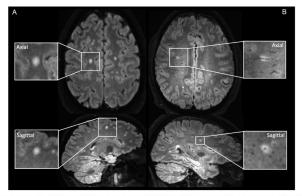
(Larger view file uploaded separately): Axial and sagittal views of 3T FLAIR⁴ brain MRI in two patients. A) Non-inflammatory lesion without CVS in a patient misdiagnosed with MS (final diagnosis migraine and cervical disc degeneration). B) Inflammatory demyelinating lesion with CVS in a patient with MS. The hypointense vein numing centrally through the hyperimeters focal lesion can be seen in both views. CVS: central vein sign.
